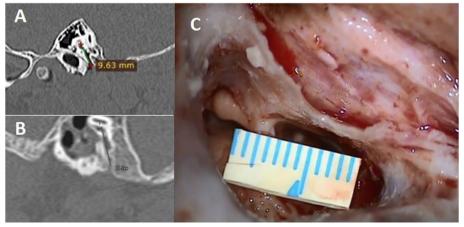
A High-resolution computed tomography (HRCT) oblique sagittal cut showing a facial recess length of 9.63 mm (measured from most superior point of vertical segment of the facial nerve to branching point of chorda tympani), B HRCT curved MPR image showing a facial recess length of 10.8 mm (measured from most superior point of vertical segment of the facial nerve to branching point of chorda tympani), and C intraoperative view showing a facial recess length of 10 mm
